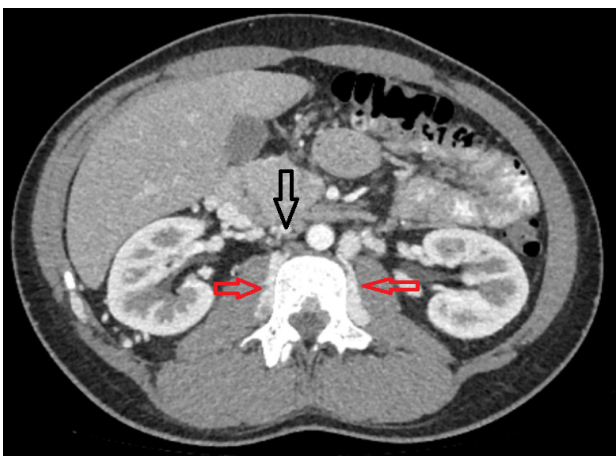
Axial view of CT scan of IVCA showing absent IVC (black arrow), dilated right and left lumbar veins (red arrow)
